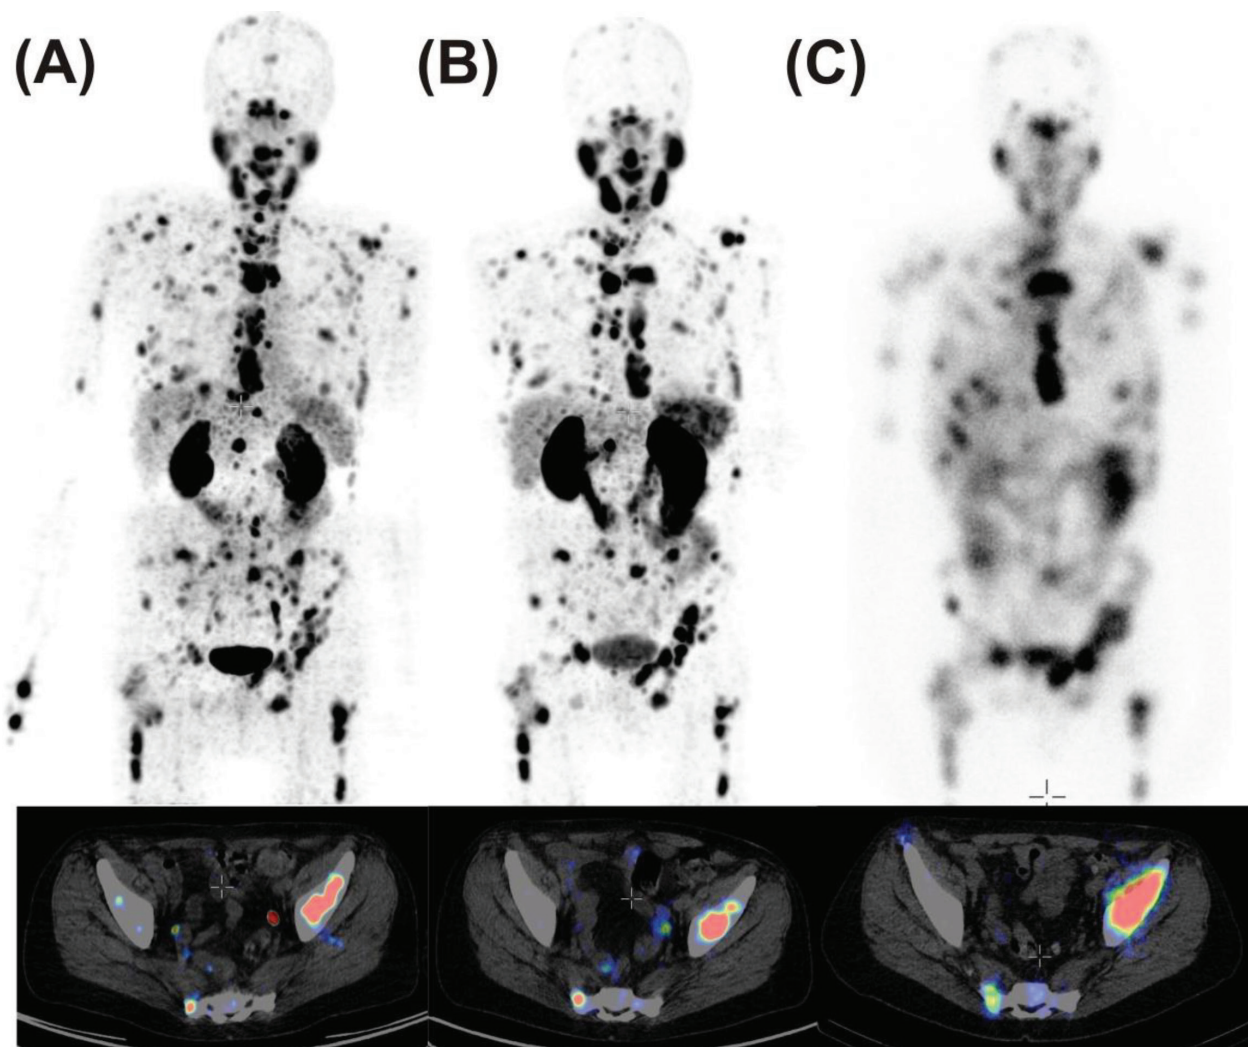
Maximal intensity projection (top) and representative slice (bottom) of PET/CT examination of a 70-year-old patient suffering of mCRPC with high tumor load using (A) [^{44}Sc]Sc-PSMA-617 (50 MBq, 60 min p.i.), and (B) [^{68}Ga]Ga-PSMA-11 (120 MBq, 60 min p.i.). (C) On the right-hand side, the planar scintigraphy (top) and a representative slice of the post-therapy SPECT/CT scan, about 24 h after application of 6.7 GBq of [^{177}Lu]Lu-PSMA-617 are shown [21].
